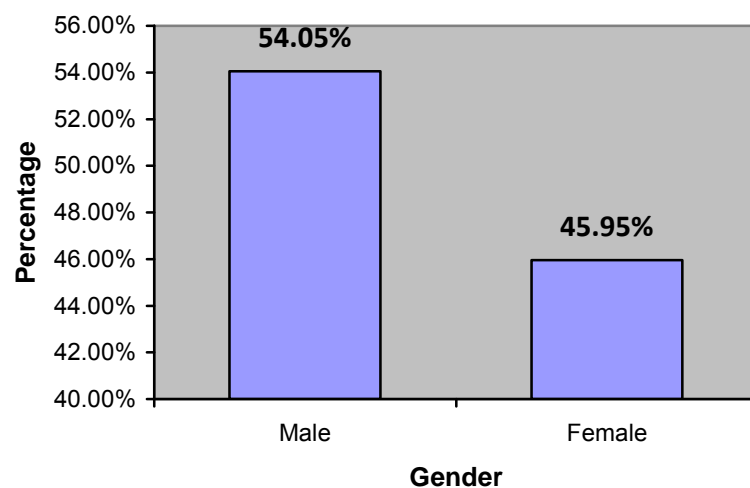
Gender distribution of patients whose radiographic and clinical records were inspected
